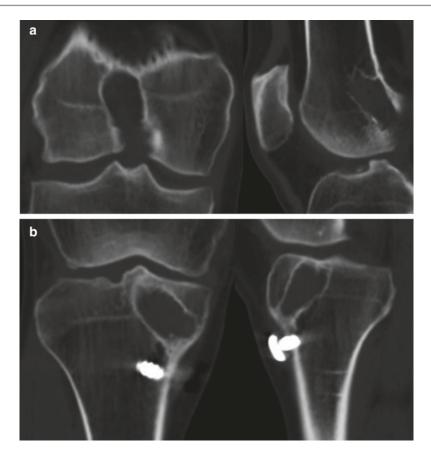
a Computed tomography of the knee showing tunnel widening in the femoral tunnel. b Computed tomography of the knee showing tunnel widening in the tibia tunnel
